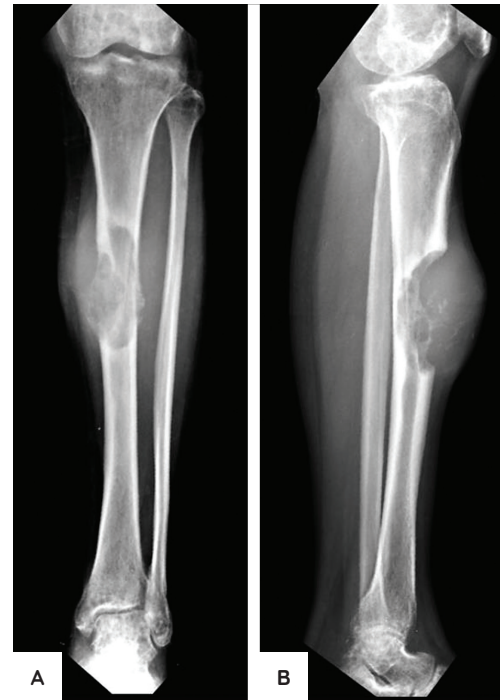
Antero-posterior (AP) (A) and lateral (B) radiographs showing the tumor on the tibial shaft.
